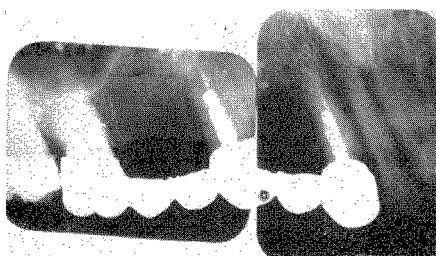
Roentgenogram taken in 1962 of the upper right bridge. Two full crowns now acted as abutment castings.
